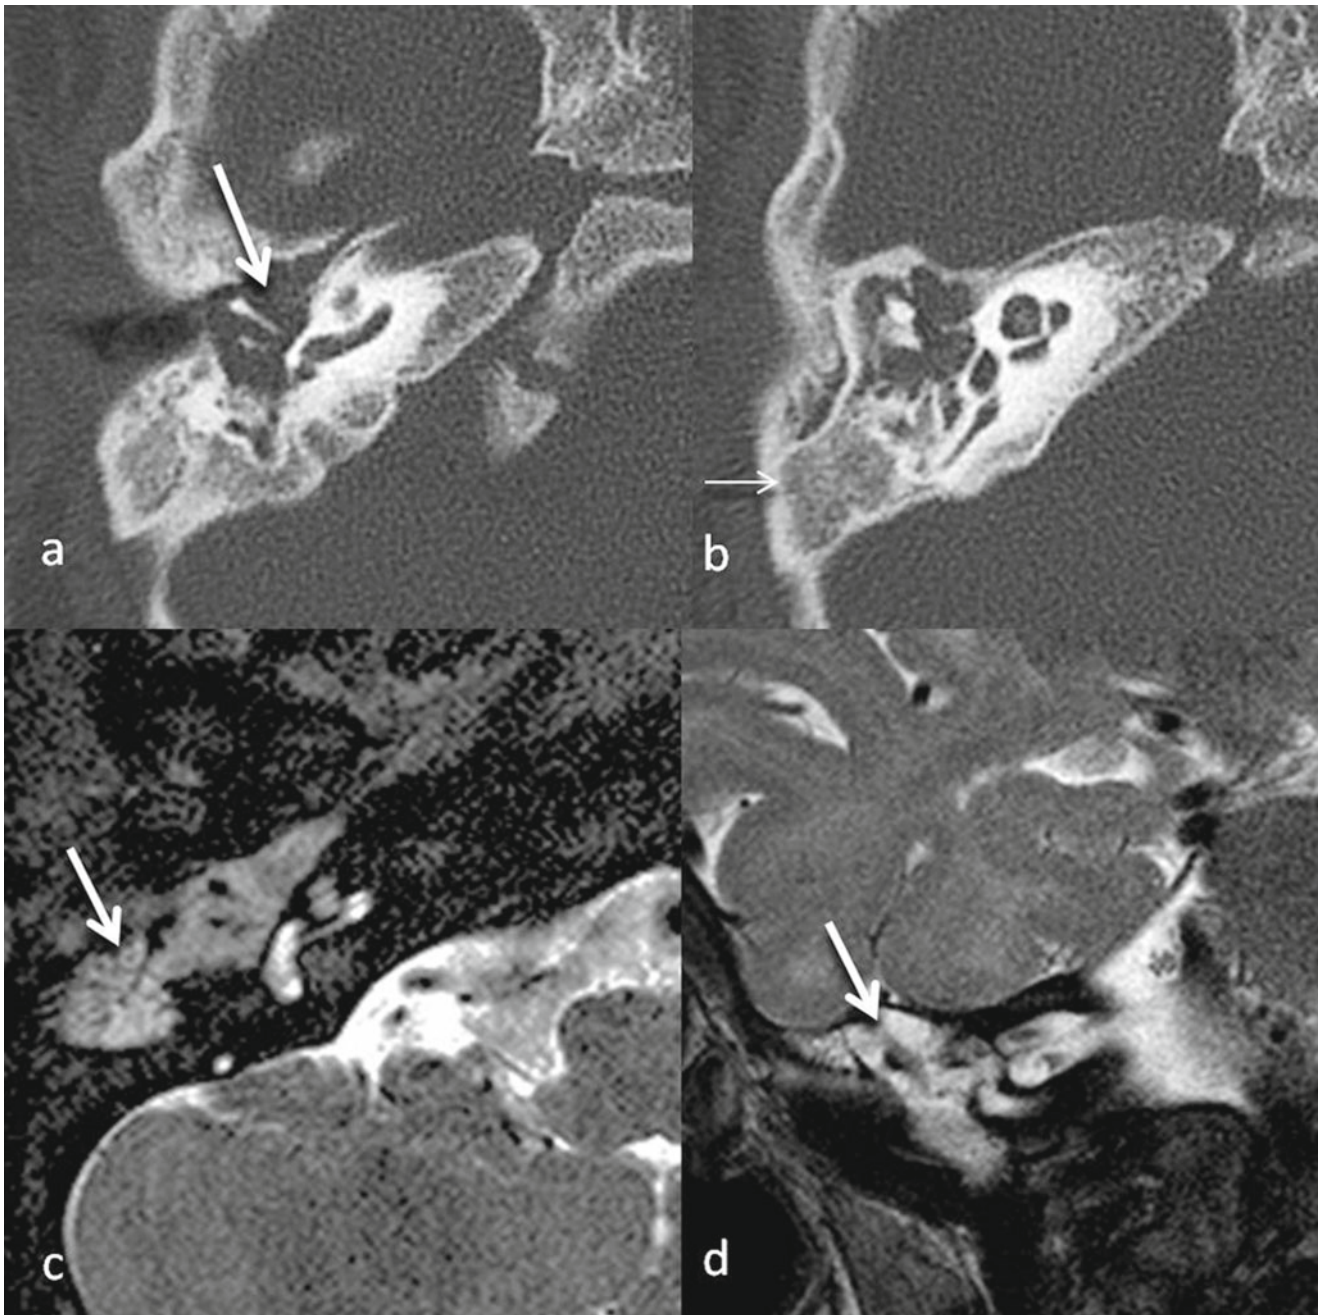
Temporal bone imaging of an 8 month old with deafness secondary to Emberger syndrome demonstrating evidence of middle ear disease with involvement of the mastoid. Axial CT (a and b) reveals
